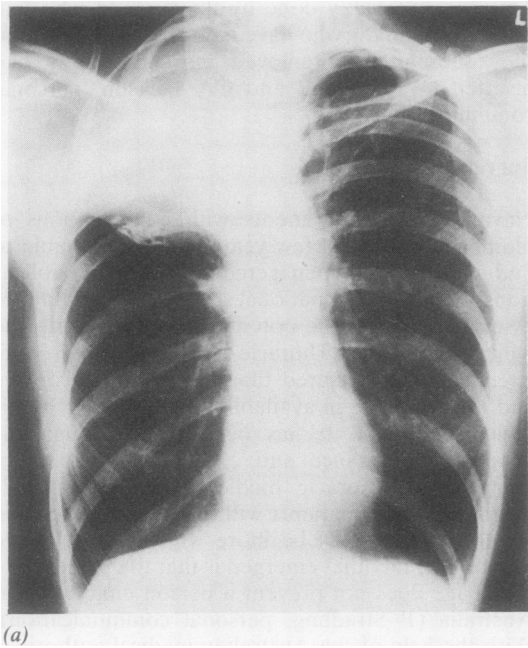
Variable radiographic appearances of polystan plombage, 20 years (a), 18 years (b) and 19 years (c) after insertion. Disorganisation in the overlying ribs is evident.
